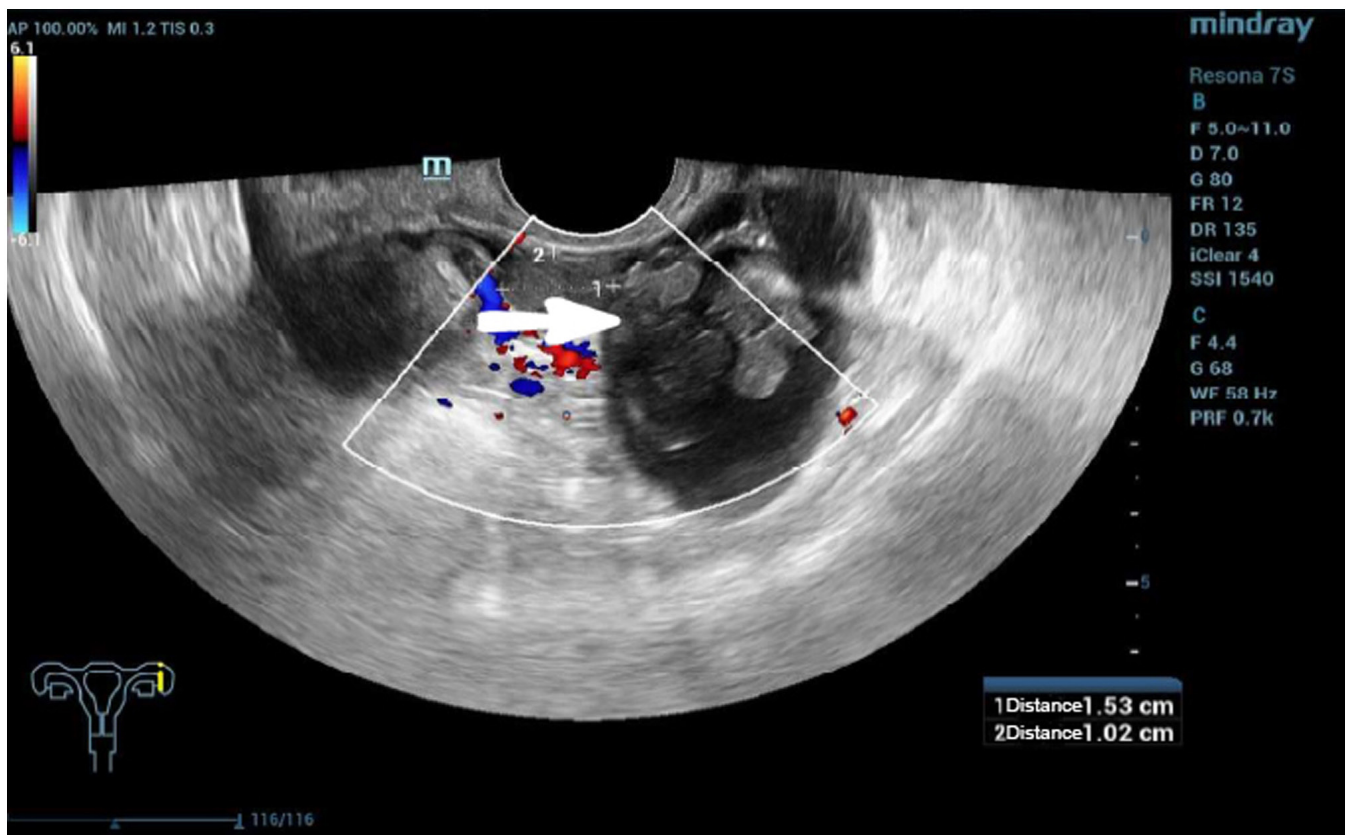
Typical ultrasound image of papillae. The white arrow indicates papillae of serous papillary adenofibroma.
